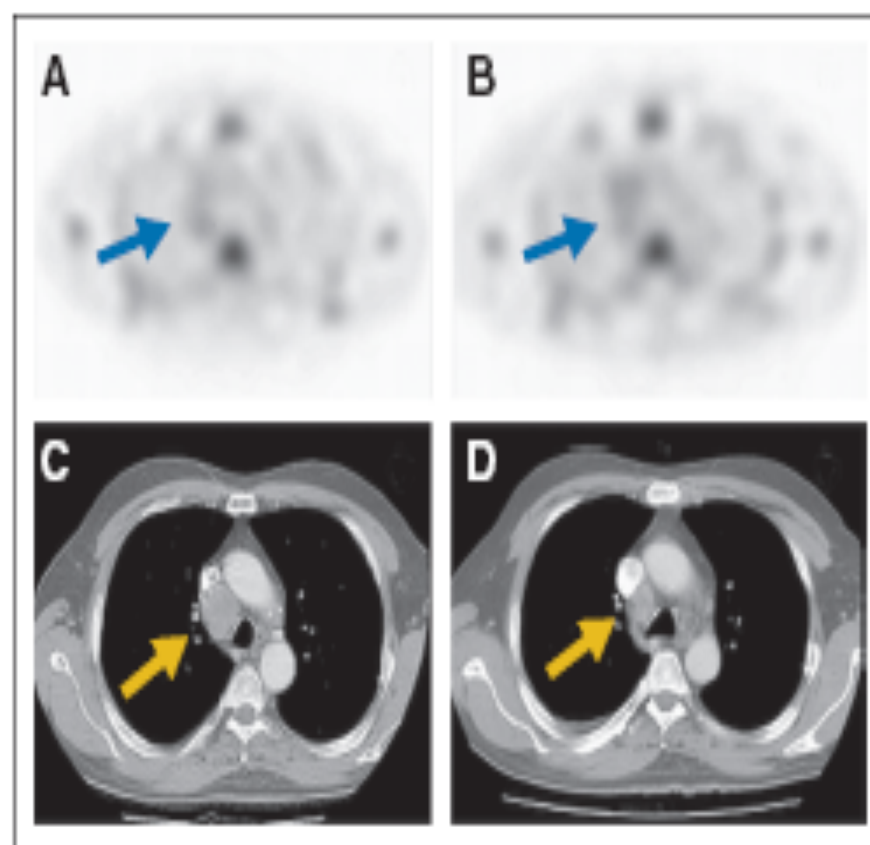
^{99m}Tc -Hynic-rh-annexin V single-photon emission tomography (A) before and (B) 48 hours after the first administration of cisplatin demonstrate increase of the tumor tracer uptake in the mediastinal lymph nodes (arrows). (C) Baseline computed tomography scan demonstrates a large right paratracheal mass with partial response on (D) follow-up computed tomography scan, obtained 4 weeks later.
